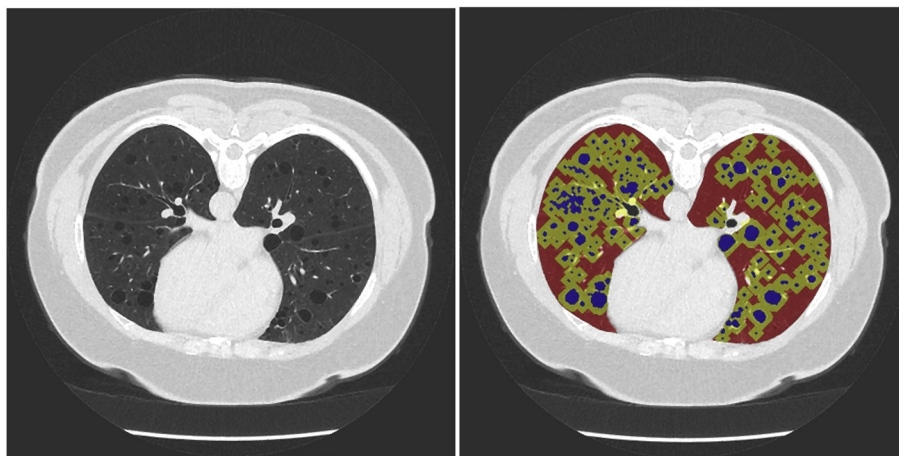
Selection of cystic regions (blue), regions near cysts (yellow), and regions away from cysts (red) in a CT examination of a patient with lymphangioliomyomatosis. For every slice in a CT study, areas occupied by cysts are summed and divided by total lung area, yielding the cyst score (the percentage of lung occupied by cysts). Image texture is calculated in all regions <10 mm from cysts (yellow) and all regions >10 mm away from cysts (red) and averaged across all slices. The difference in texture between regions near and away was used as a measure of lung parenchymal degradation. Increases in texture measures suggest increased degradation of lung parenchyma surrounding cysts.
